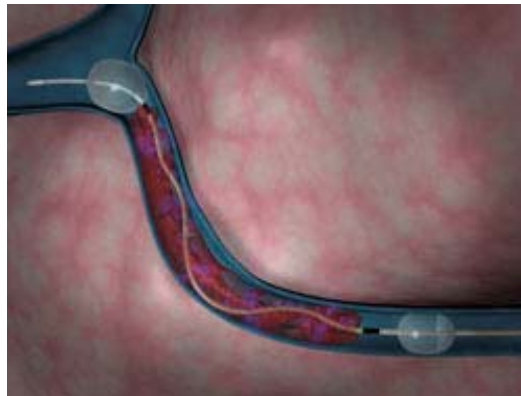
Ultrasonic pressure waves encompass entire vessel.
